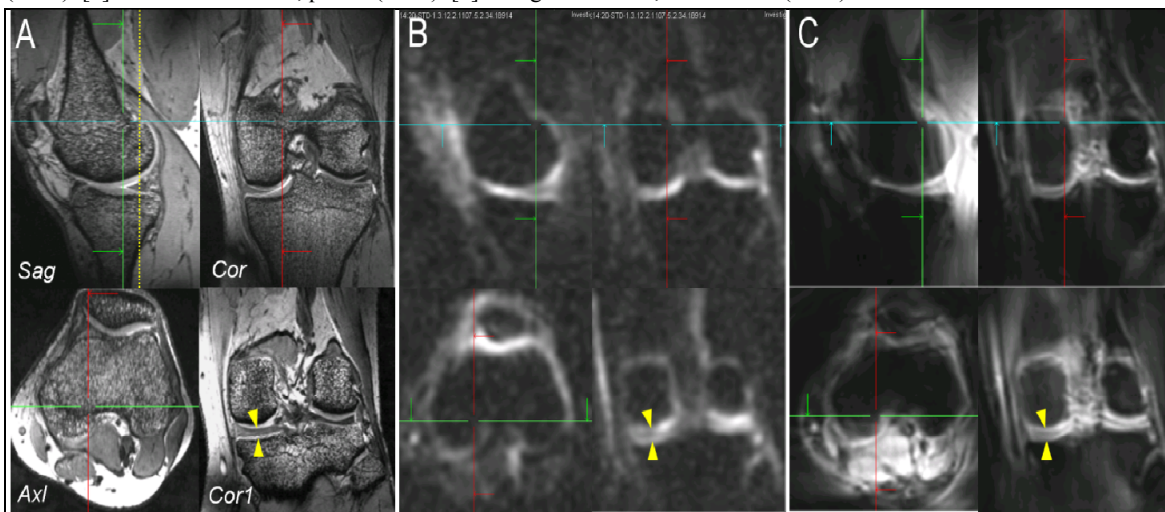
$^1\text{H}/^{23}\text{Na}$ knee MR imaging at 7T. Proton (A), sodium (B), and ultra-short TE (C) images of subject 1 acquired; sagittal (red line), coronal (green), and axial (cyan) plane. All compartments of knee cartilage (patellar, femoral and tibial) are well demarcated on each image (A-C). Note the menisci and separation between femoral and tibial cartilages (yellow arrowheads on A-C)
